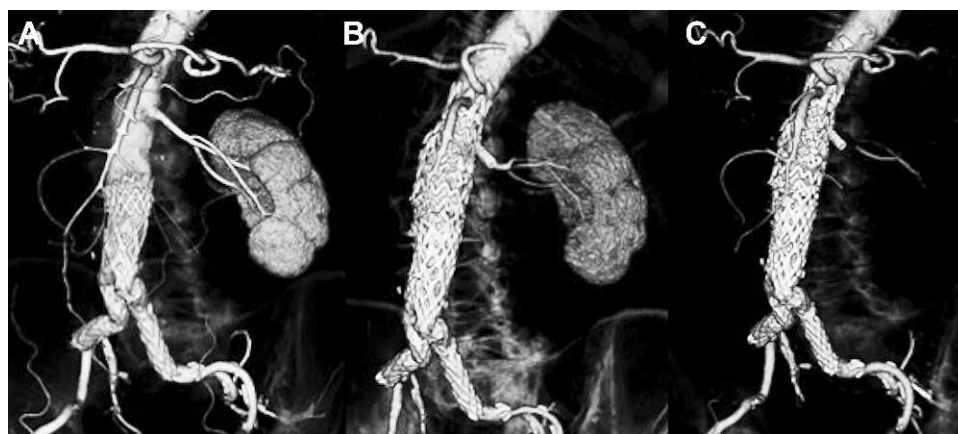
◆ Three-dimensional CT scan reconstructions before (A) and after (B) EVAR with left renal chimney stent-graft for juxtarenal aortic aneurysm; (C) 3-month CT scan showing renal chimney stent occlusion.
